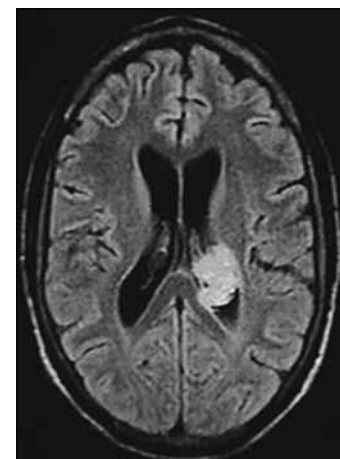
T2-weighted fluid attenuated inversion recovery axial scan of the patient showing a mass in the body and atrium of the left lateral ventricle which is hyperintense compared to the normal white matter
